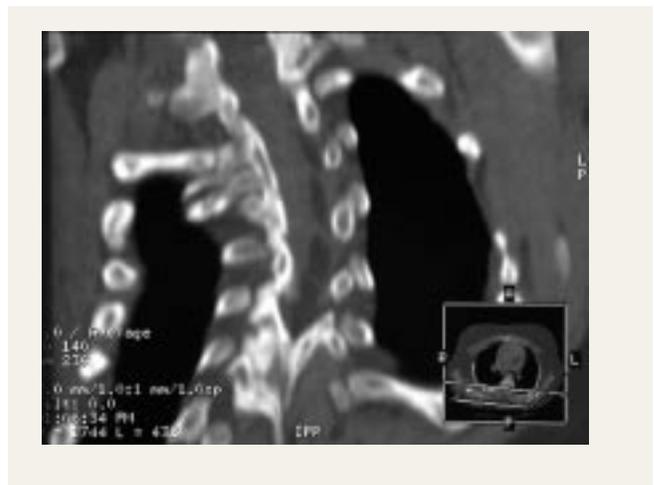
CT-scan of a 2-year old with VACTERL syndrome and progressive congenital lordeo-scoliosis with bilaterally diminished lung volumes and hypoplastic hemithorax. Multiple rib and vertebral body anomalies are present including a bony postero-lateral bar and concave rib fusions. Conventional treatment of this problem would be by anterior and posterior spinal fusion, which likely would halt the progressive curvature, but further shorten an already short thoracic spine and contribute to hypoplastic thorax and respiratory insufficiency (TIS). Alternatively, expansion thoracostomies and insertion of VEPTR device with repetitive distraction offers control of the progressive curve during growth while expanding the hemi thorax and encouraging lung growth. Ultimately spinal fusion would probably be needed, but preferably at an older age, after more spine, lung and thoracic growth was achieved.
